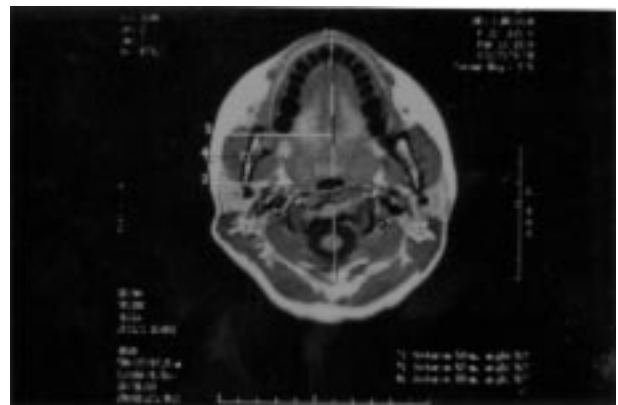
Sagittal MRI scan taken on the third day postoperatively (Tenoxicam) .
